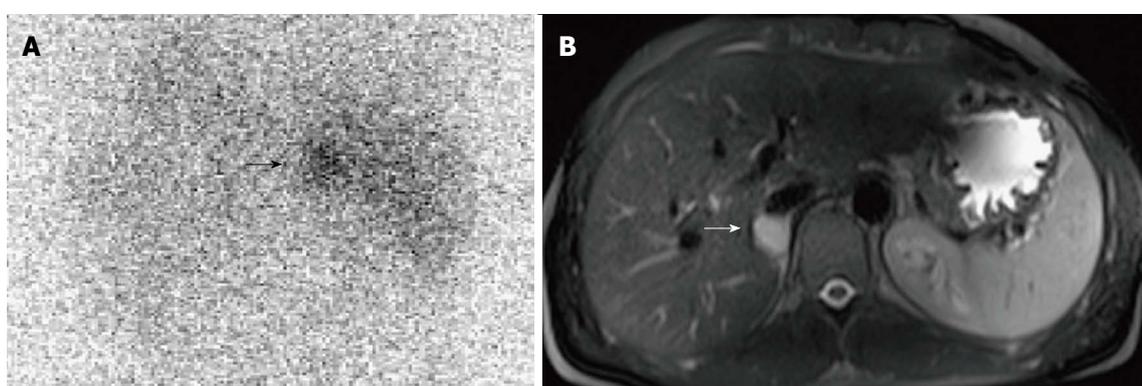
Right benign non-hypersecreting pheochromocytoma. A: Abdominal posterior scan of I-131 metaiodobenzylguanidine scintigraphy demonstrates abnormal (faint) focal uptake in the right adrenal (black arrow) where a small mass was detected by magnetic resonance (MR); no detectable tracer uptake in the left adrenal bed; B: T2-weighted axial MR with fat-suppression detects a small right adrenal lesion hyperintense compared to liver signal intensity (white arrow).
